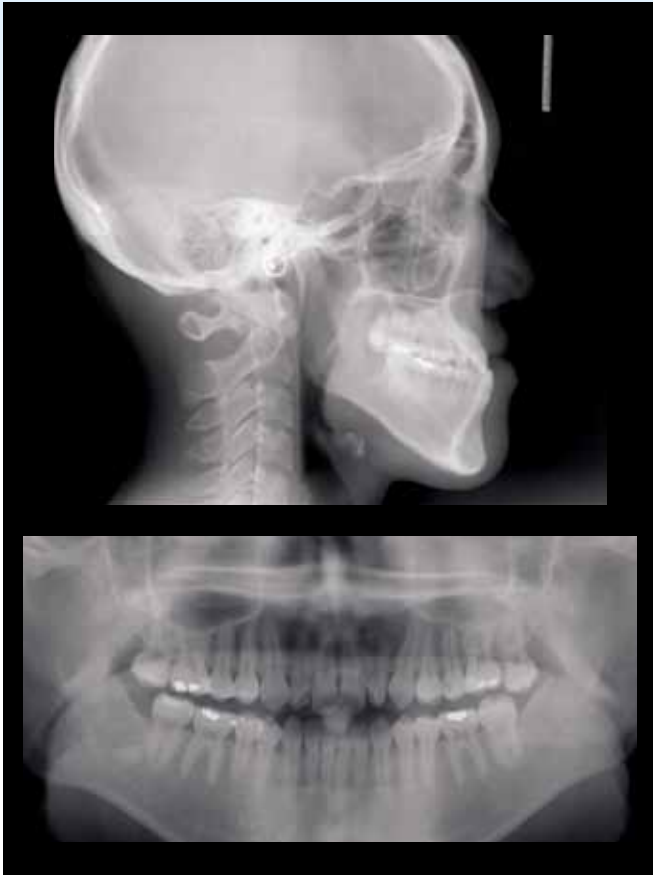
Pretreatment pano and ceph radiographs
